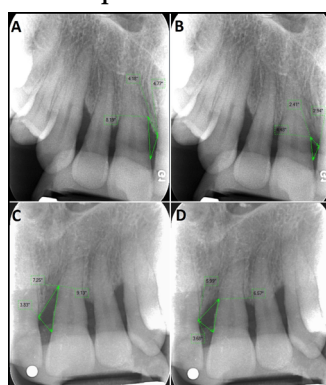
Preoperative and postoperative computerized digital radiographs: (A) Baseline intrabony defect mesial to upper right central incisor treated with PPF; (B) 6 months follow up showing intrabony defect depth resolution. (C) Baseline intrabony defect mesial to upper left central incisor treated with n-HA+PPF; (D) 6 months follow up showing intrabony defect depth resolution.
